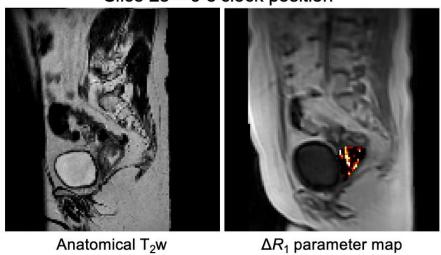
Paired  $T_2$ w and OE-MRI images from two opposite sides of the tumour -3 o'clock (top row) and 9 o'clock (bottom row).
